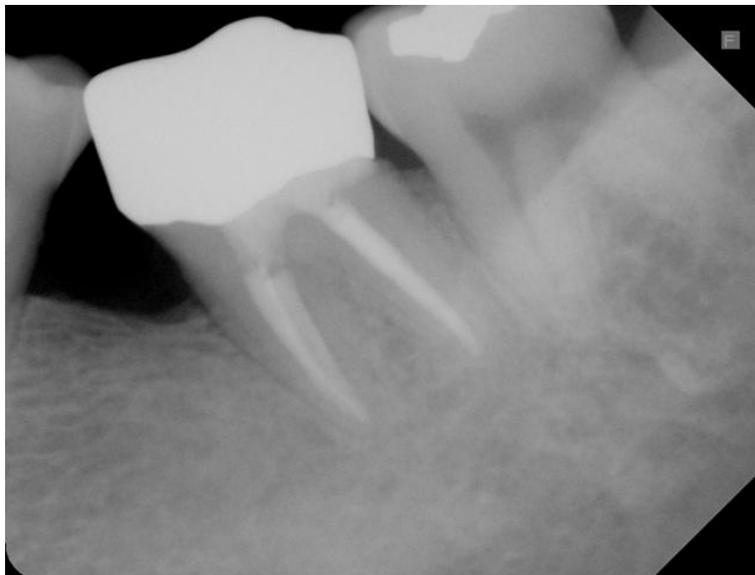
Radiographic appearance of roots of tooth #36 categorized as successful. The lamina dura can be traced around the entire length of the roots.
